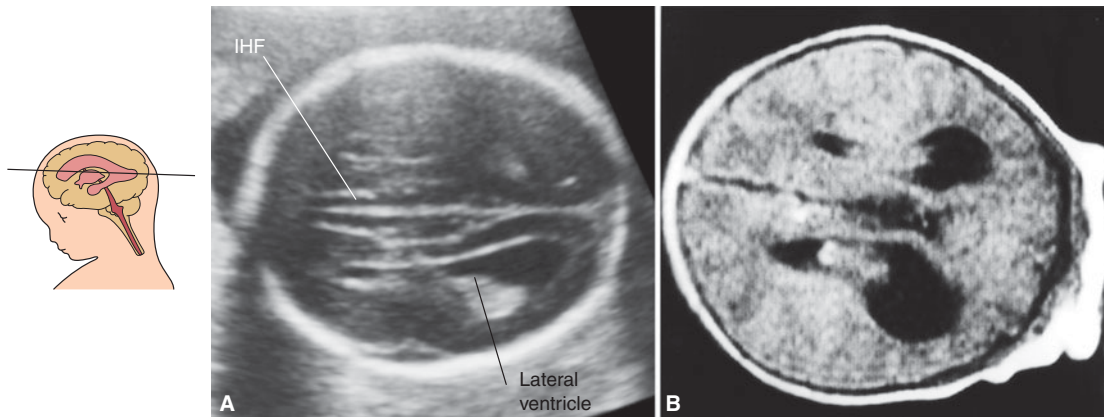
Ventriculomegaly with tear-shaped lateral ventricles is a very typical finding of agenesis of the corpus callosum. (A) fetal sonogram; (B) postnatal computed tomography (CT). The IHF is typically enlarged. (Reproduced, with permission, from Pilu G, Sandri F, Perolo A, et al. Sonography of fetal agenesis of the corpus callosum: A survey of 35 cases. *Ultrasound Obstet Gynecol.* 1993;3[5]:318–329.)
